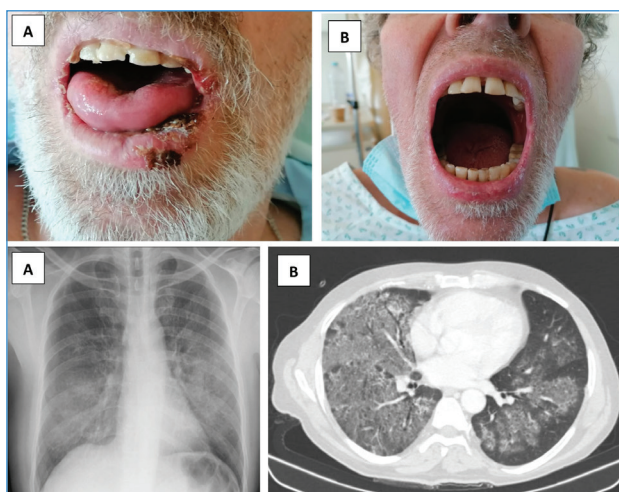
Oral ulcers prior (A) and after glucocorticoids (B). Chest PA radiography (C) and CT (D) show diffuse alveolar haemorrhage.
